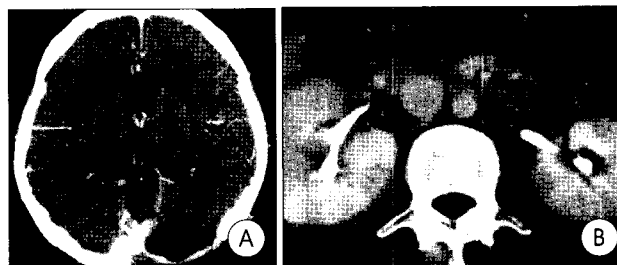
A : The postoperative brain computed tomography shows a successfully removed and collapsed previous abscess cavity. B : After 6 weeks of antibiotic therapy for eradication of the brain abscess, the abdomen computed tomography reveals normalization of renal calyx pattern and much reduction of multilobulated cystic lesion. This looks like a simultaneous infectious abscess cavity, rather than a tumor cyst.
